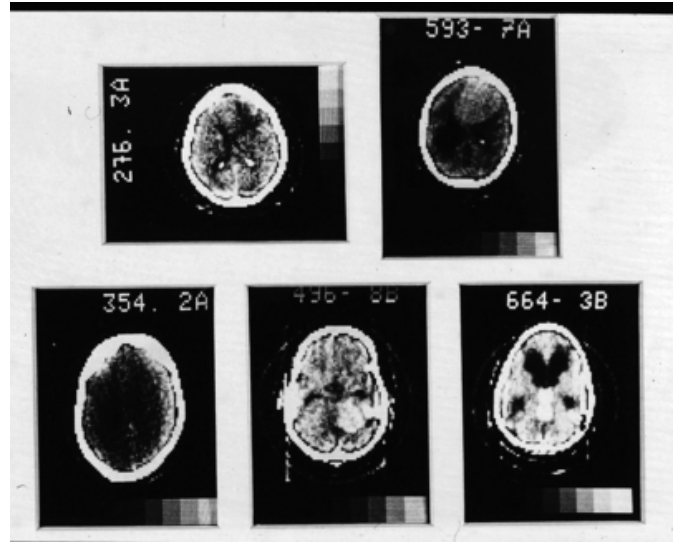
Initial test images after installation of the first commercial CT scanner at Atkinson Morley's Hospital in 1971 (Photograph courtesy of St. George's, University of London).
